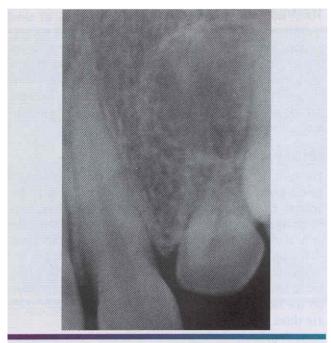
• Tuberous sclerosis. Periapical radiograph exhibiting a well-defined radiolucency apical to the maxillary left lateral incisor. Biopsy revealed an intraosseous fibrous proliferation.
